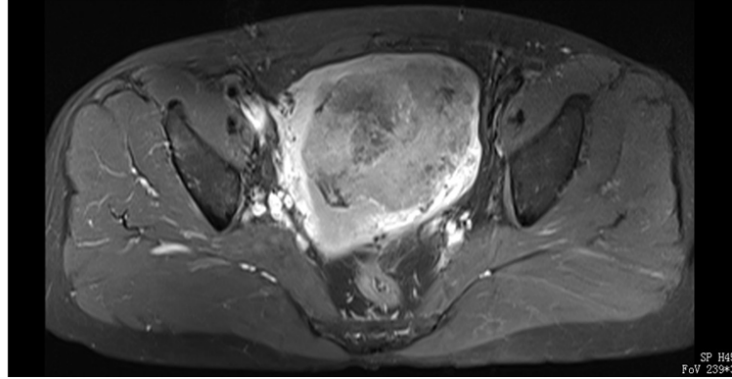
Pelvis magnetic resonance imaging (MRI) confirmed a 12 cm × 11 cm × 10 cm mass with obscure boundary in pelvic cavity.
